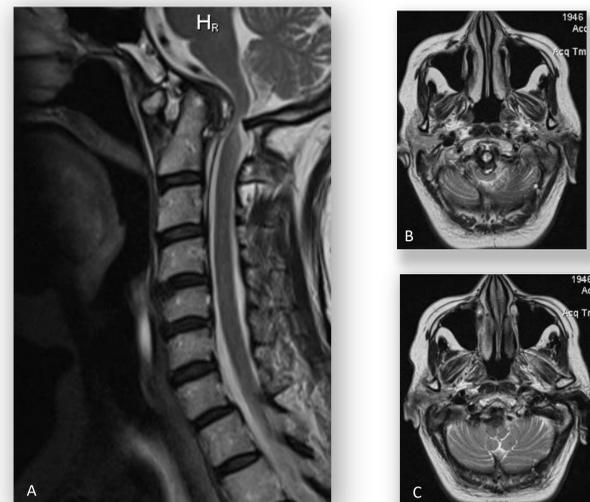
sagittal (A) and axial T2 MRI (B-C) views of a retro odontoid pannus in a 56-year-old woman affected by rheumatoid arthritis
